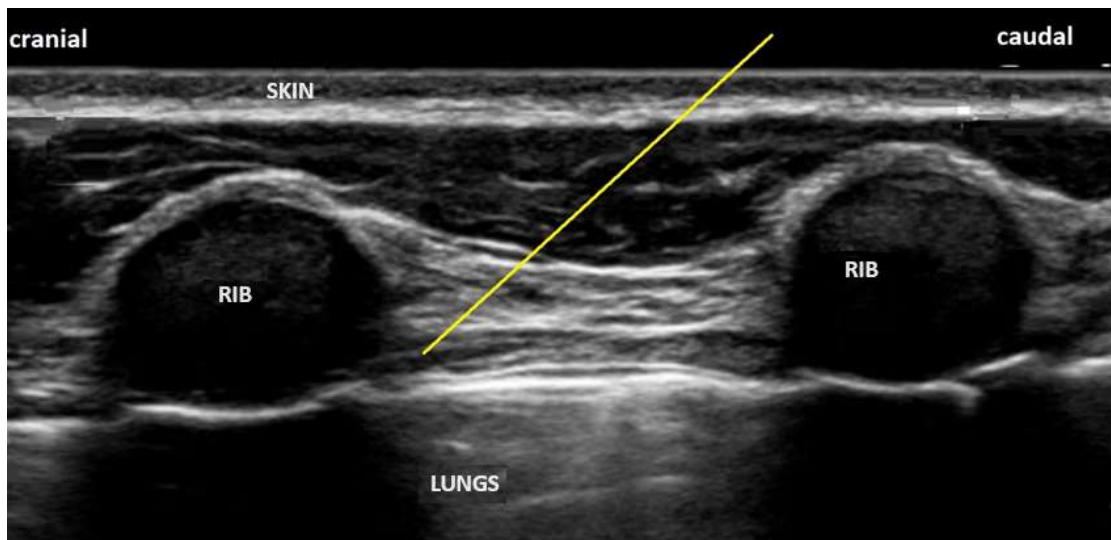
Ultrasound visualization of the intercostal space. The yellow line shows the needle guidance during blockade (from the author's archive).
